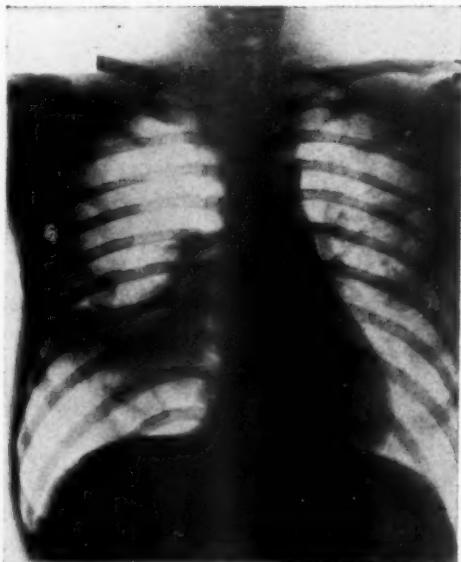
Case 7. Artificial right pneumothorax. Roentgenogram taken after an injection of 500 c.c. of gas.
